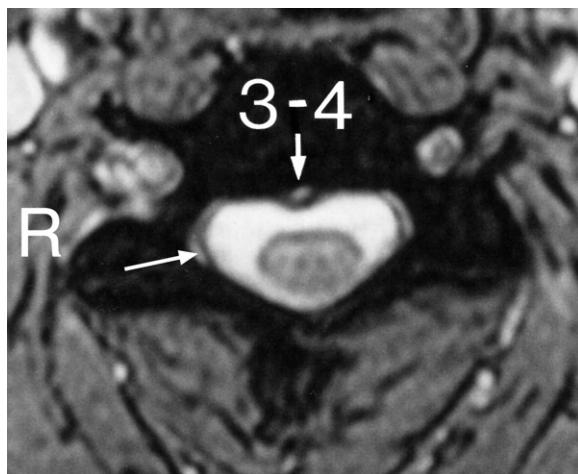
Cervical spine MRI axial T2-weighted C3-4 image. Note the central posterior disc protrusion (small white arrow). Although the protrusion does not compress the spinal cord itself, it does efface the pain sensitive anterior part of the dural tube. (The lateral part of the dural tube is shown by the long white arrow.)
